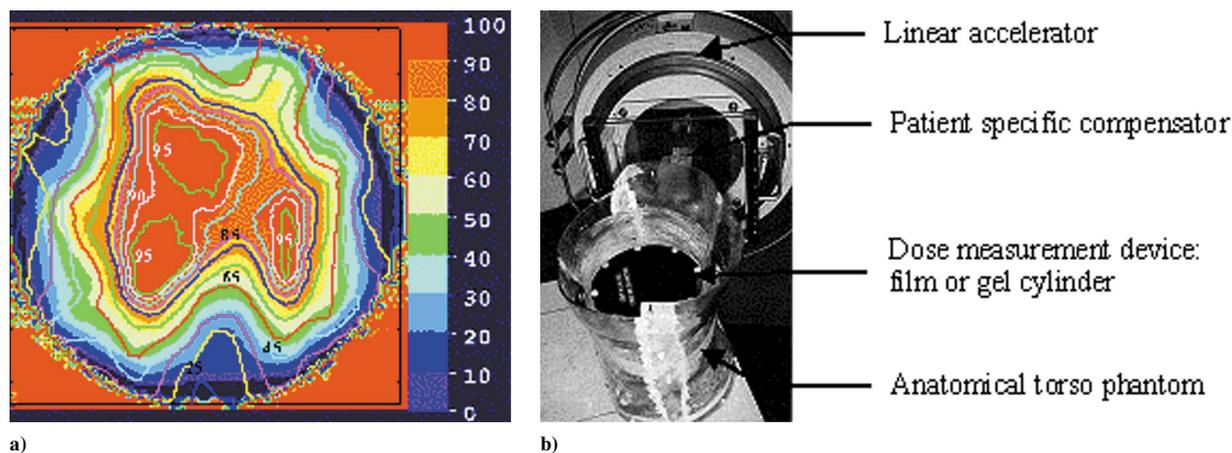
[a] IMRT isodose distribution obtained with film dosimetry overlaid on the MR image of the bis-acrylamide-nitrogen and gelatine (bang) gel also used to measure the radiation dose delivered to the PTV and adjacent tissues. [b] Compensator + linear accelerator based IMRT set-up used for the experimental measurements
